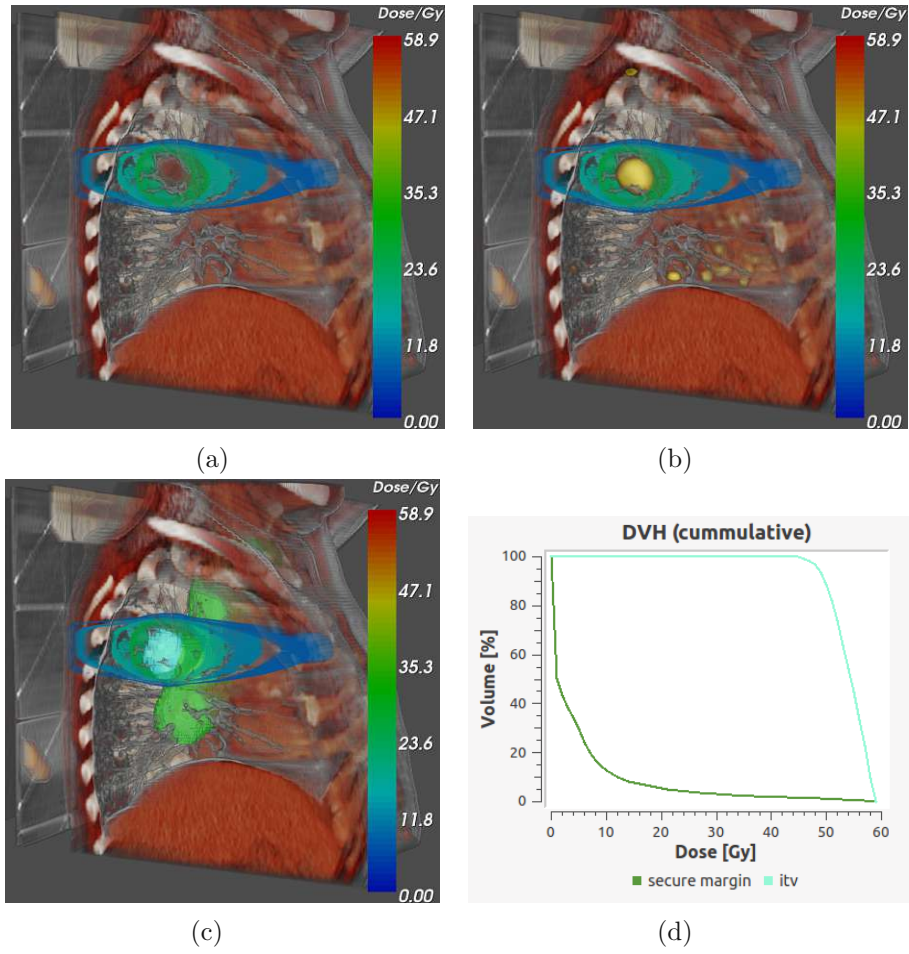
Fusion of dose information: (a) Fusion of the planning CT and four different isodose surfaces. (b) Additional fusion of PET. (c) Additional fusion of segmentation data sets. (d) Corresponding DVH of the segmentation data sets from (c).
